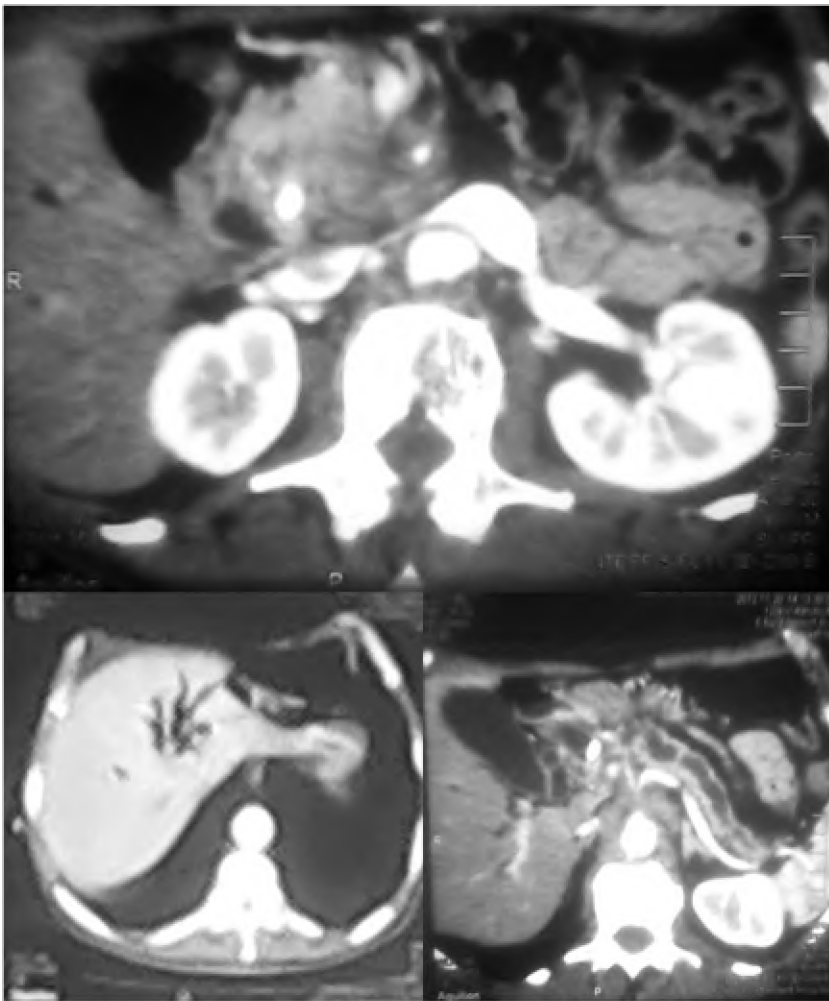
50 years old male presented with obstructive jaundice. Multislice CT axial image showed pancreatic head lesion, encasing the celiac trunk and significantly dilated pancreatic duct as well as intrahepatic biliary radicles dilatation. The lesion confirmed by fine needle aspiration biopsy as adenocarcinoma.
